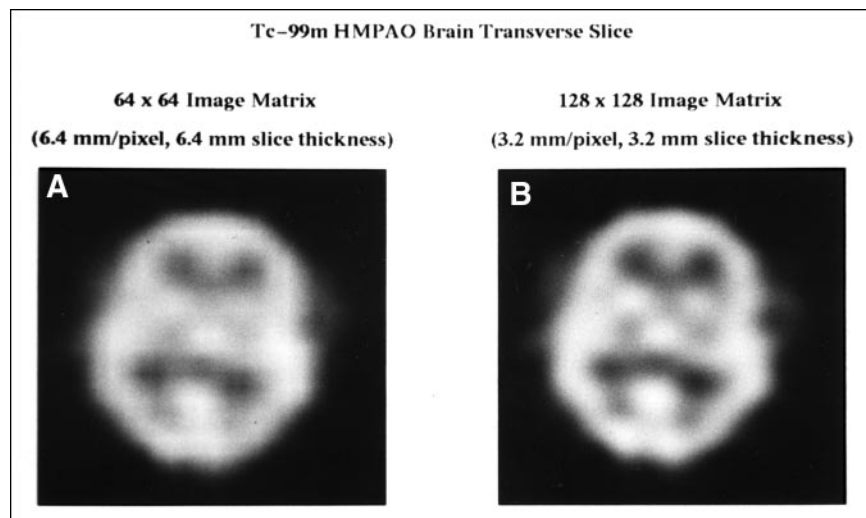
(A) 64 × 64 and (B) 128 × 128 SPECT reconstructions of the central transverse slice from a ^{99m}Tc-HMPAO brain SPECT study. Equivalent reconstruction filtering was used (10th order Butterworth, 0.75 Nyquist for 64 × 64 and 0.375 Nyquist for 128 × 128). Not only is the resolution within each slice improved for 128 × 128, with equivalent smoothing, but the slices are only half as thick compared with 64 × 64, leading to improved resolution in the third dimension (i.e., between slices).
